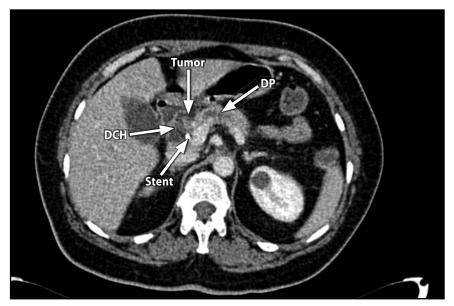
CT scan: DP – ductus pancreaticus (pancreatic duct). DCH – ductus choledochus (common bile duct)
